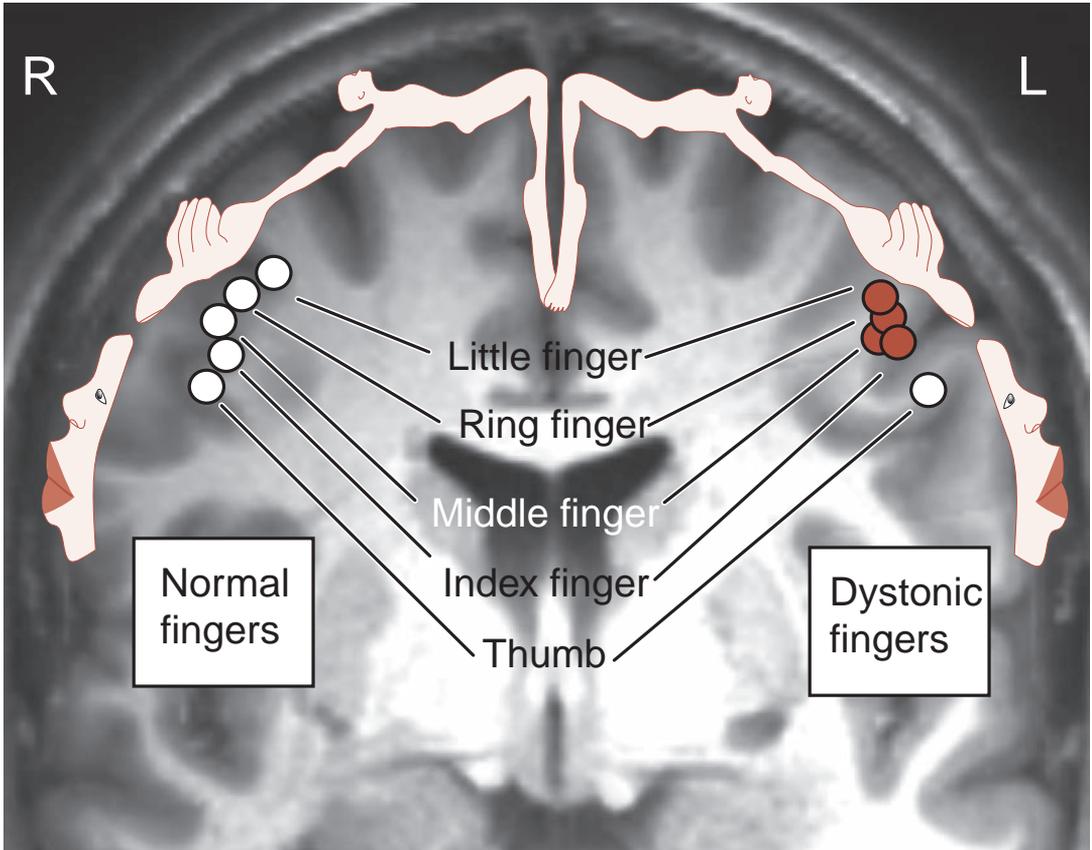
● The circles are functional representations of the fingers from the right and left hands of a musician with focal dystonia of the left hand. The response from the somatosensory cortex is superimposed on a MRI. Note the fusion of the representations for the fingers from the affected left fingers that is not seen with the separated fingers from the right hand. The thumb—a digit not requiring as much movement when playing—is unaffected. (Adapted from Elbert T, Candia V, Altenmüller E, et al. Alteration of digital representations in somatosensory cortex in focal hand dystonia. *Neuroreport*. 1998;9(16):3571-3575.)
